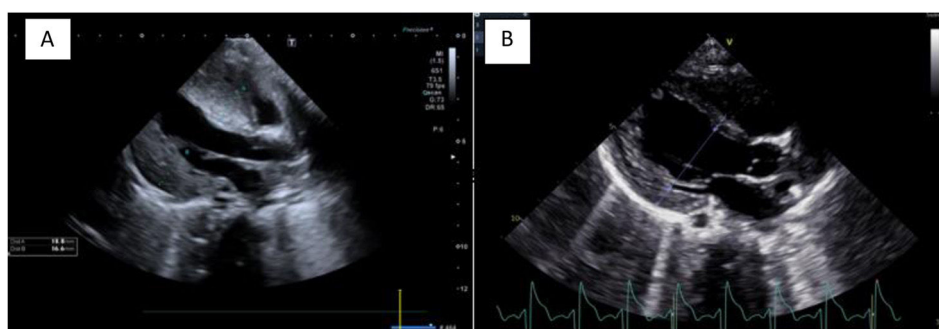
(A) Pretreatment parasternal long-axis view. (B) Post-treatment parasternal long-axis view.
